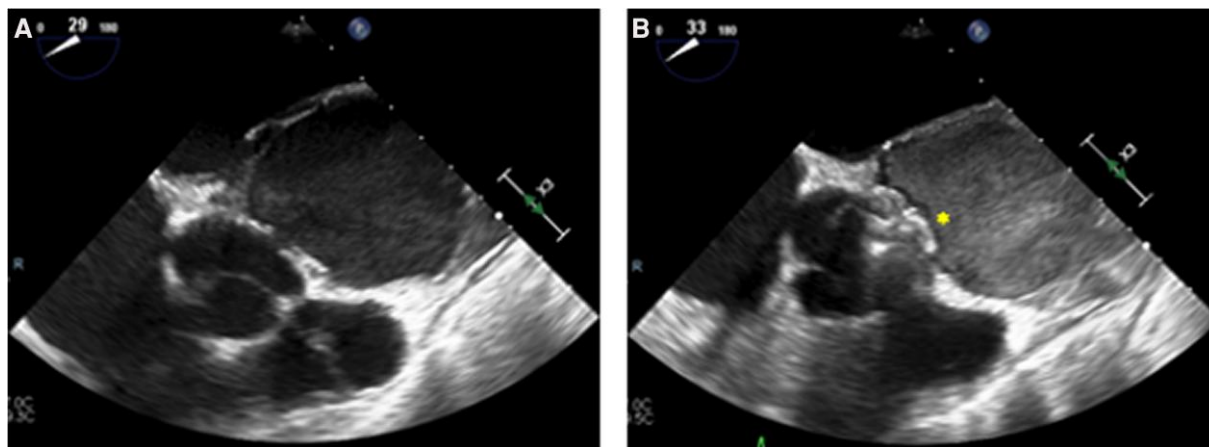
Exclusion of the sinotubular junction ascending aortic pseudoaneurysm with an Amplatzer atrial septal defect (ASD) occluder on transoesophageal echocardiography. (A) Identification of pseudoaneurysm. (B) Confirmation of the ASD occluder device placement. (* denotes the location of the Amplatzer ASD occluder).
